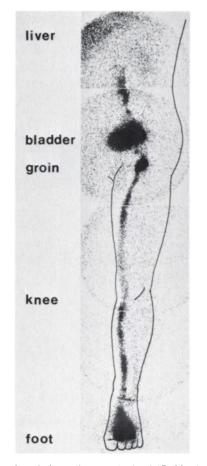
Lymphoscintigram in man obtained 45–60 min after interdigital injection of 1.0 ml (0.5 mCi) of Tc-99m-labeled dextran. Lymph vessel of leg is well visualized, along with inguinal, pelvic, and para-aortic lymph nodes. As dextran slowly enters the blood stream, liver, kidney, and urinal bladder show uptake of activity.
